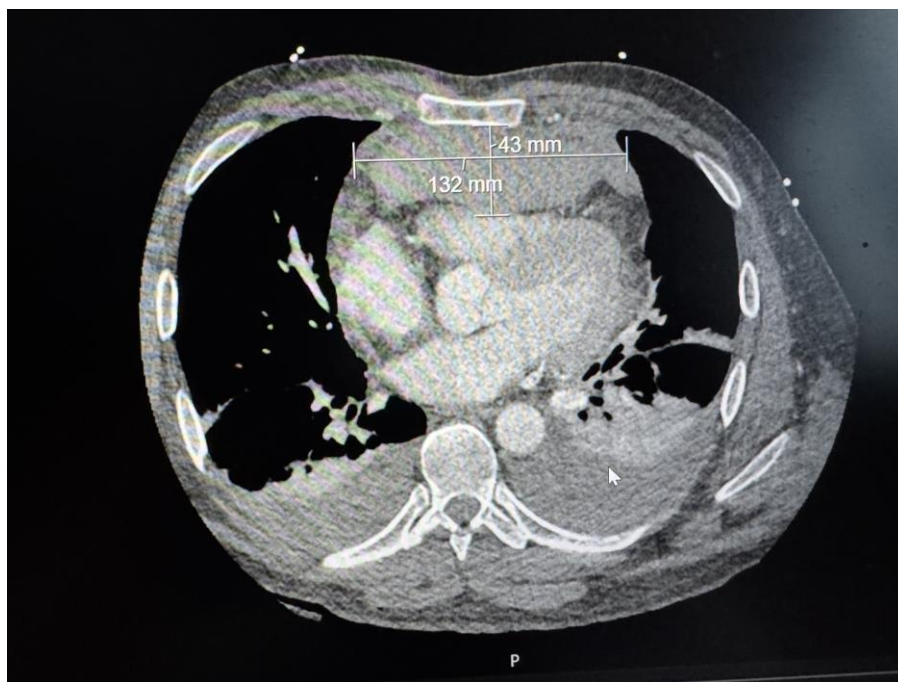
Late CT scan showing sternal fracture with increased size retrosternal haematoma compressing the right ventricle.
